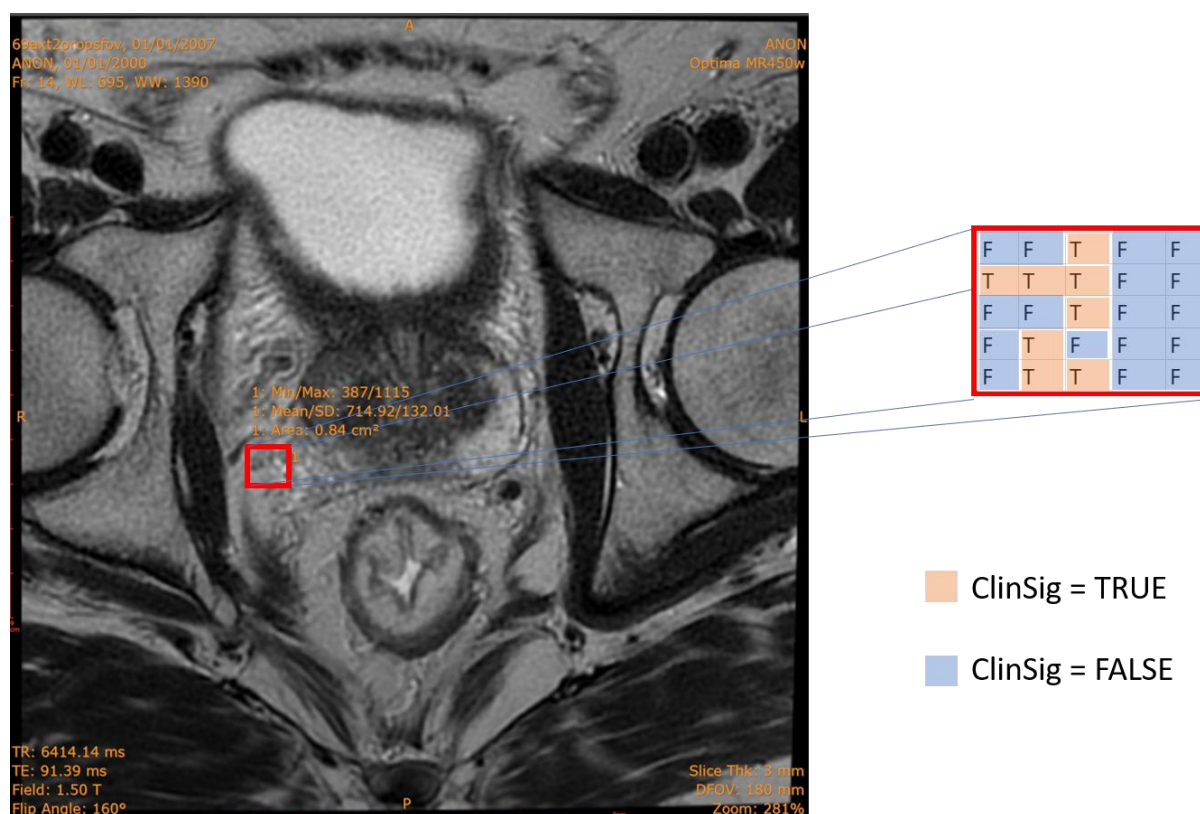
Application of the model onto an MRI image from the Clatterbridge Cancer Centre
